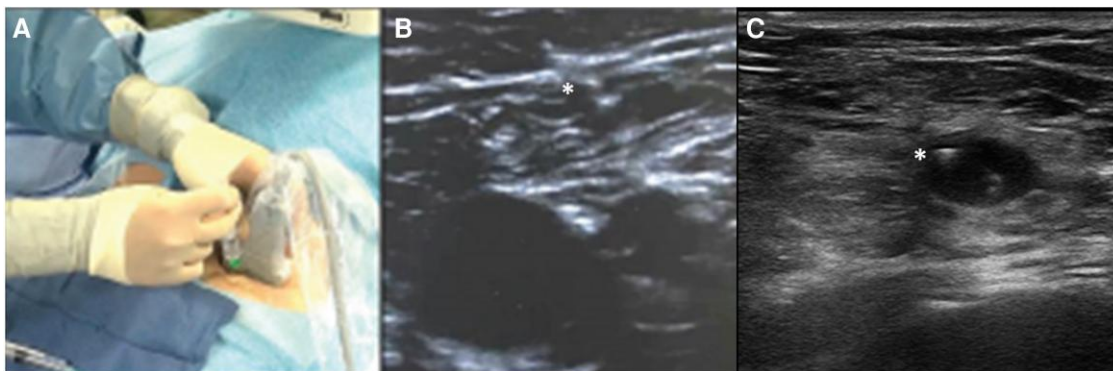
Vascular ultrasound. (A) Example of an echo-guided puncture. (B) Needle visualization (*) during entry point selection. (C) Accurate visualization of vessel wall to avoid calcified location.
